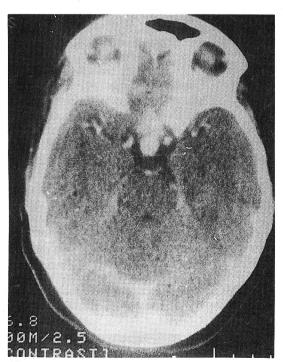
CT scan head demonstrates the enhancing high attenuating mass in the sellar region.
